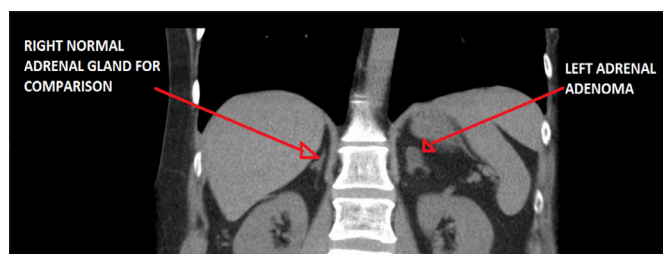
Coronal section of adrenal adenoma on CT scan.
